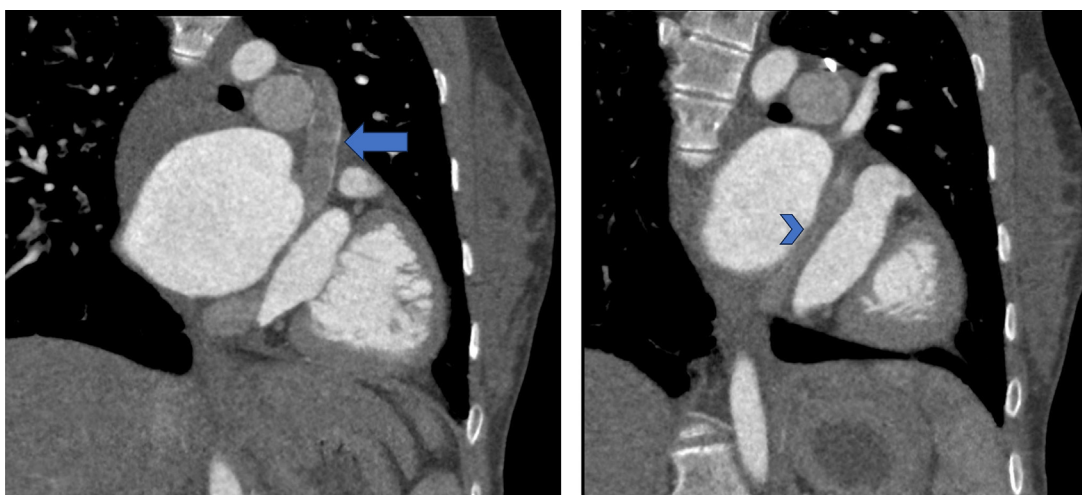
Two images of cardiac CT scans, oblique sagittal views, show persistent left-sided SVC (arrow), draining through the coronary sinus (arrowhead) into the right atrium.
